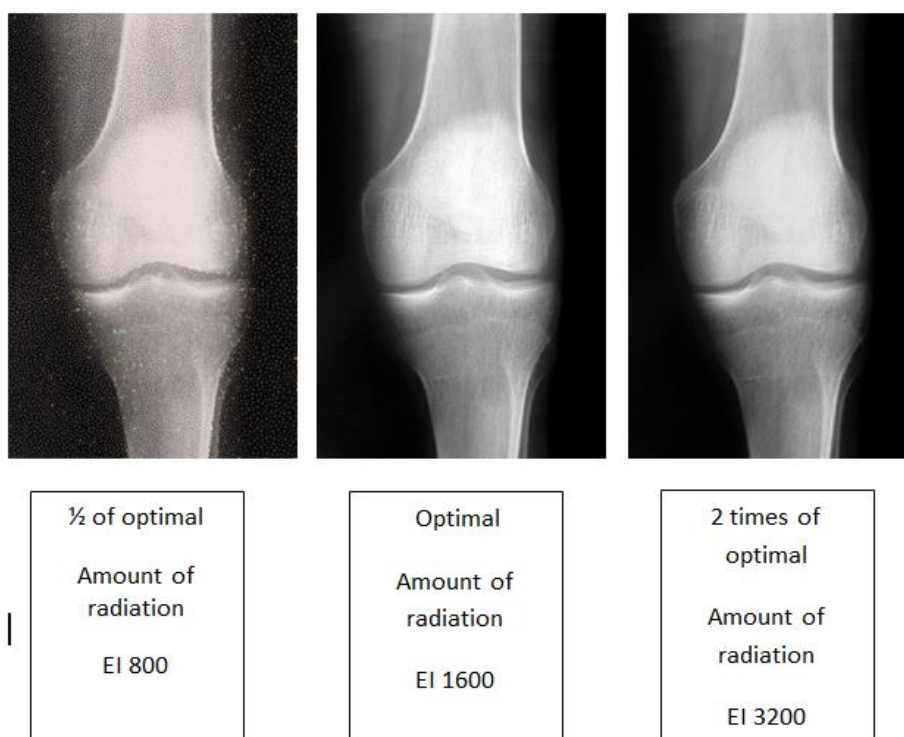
shows three radiographs exposed to different amount of radiation. All radiographs have very similar brightness and contrast because of the autocorrecting algorithm. However, the underexposed radiograph has more quantum noise which manifests itself as graininess. In addition, all images have different exposure indices (EI).
